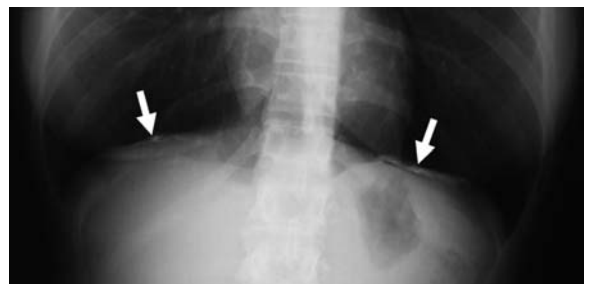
Postero-anterior chest radiograph shows diaphragmatic calcified pleural plaques seen in profile (arrows), parallel to the X-ray beam
